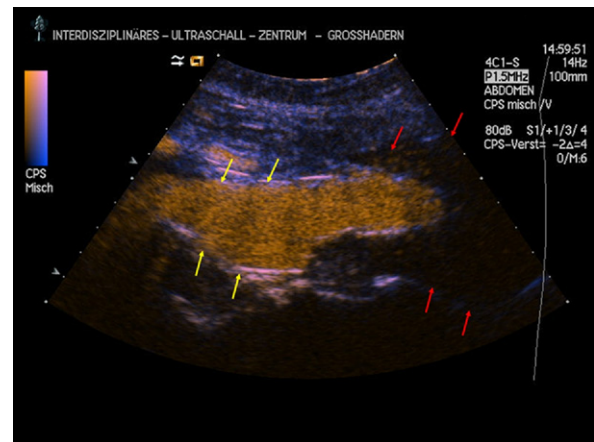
Intraoperative contrast-enhanced ultrasound (iCEUS): proximal infrarenal landing zone. iCEUS demonstrating complete proximal sealing of the stent graft. The yellow arrows show the sealing of the stent graft along the wall of the excluded proximal aortic segment. Proximal stent graft release is just below the aortic kinking, as intended. Red arrows show contrast air bubbles within the aneurysm sac, as expected, because distal aortic stent graft extension has not yet been performed. This picture would otherwise be identical to a distal type II or III endoleak.
